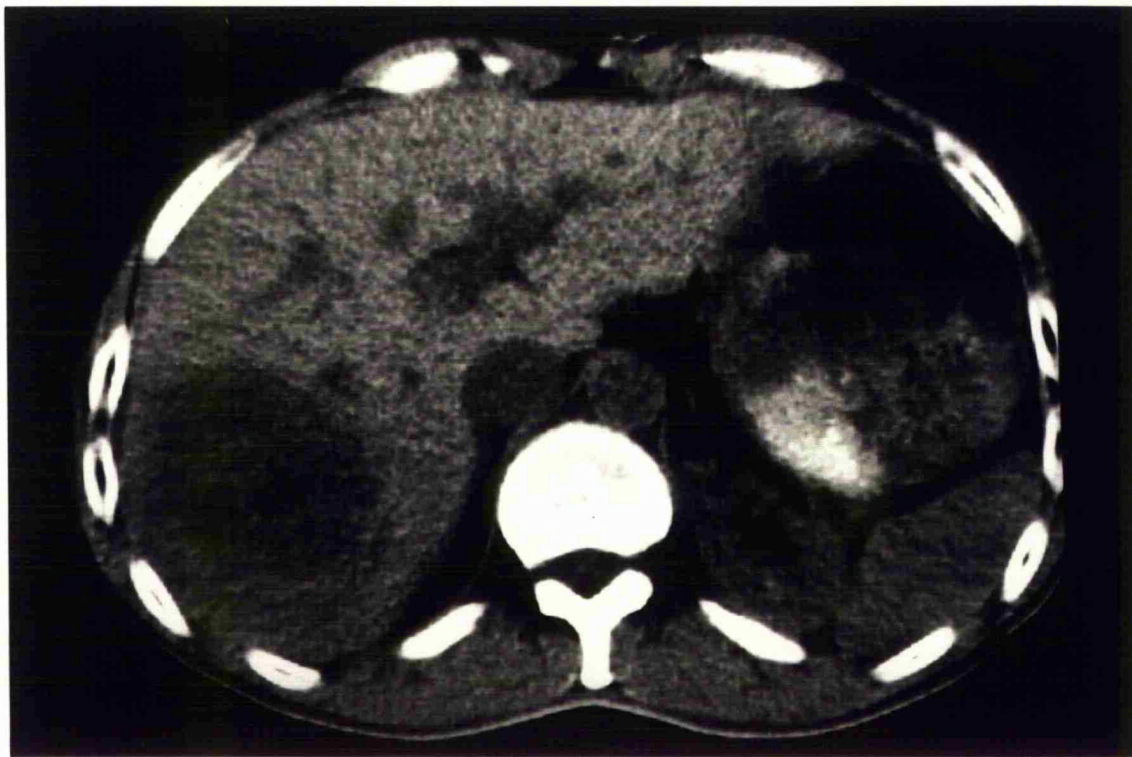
Unenhanced CT from case 3: hepatic metastases.
